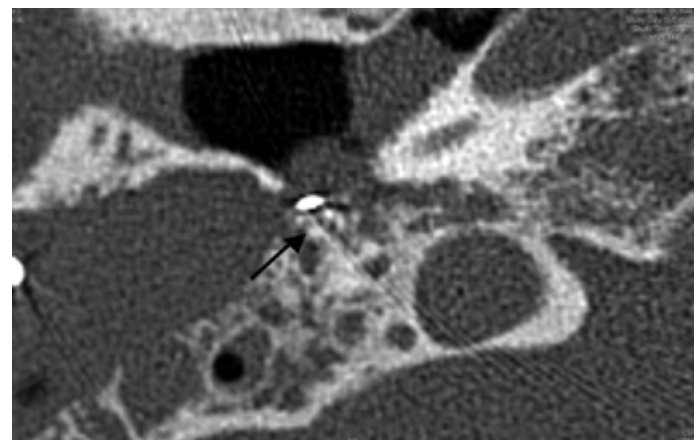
Axial HRCT of a right-sided temporal bone showing an example of a dehiscence of the MPFN (indicated by →)
